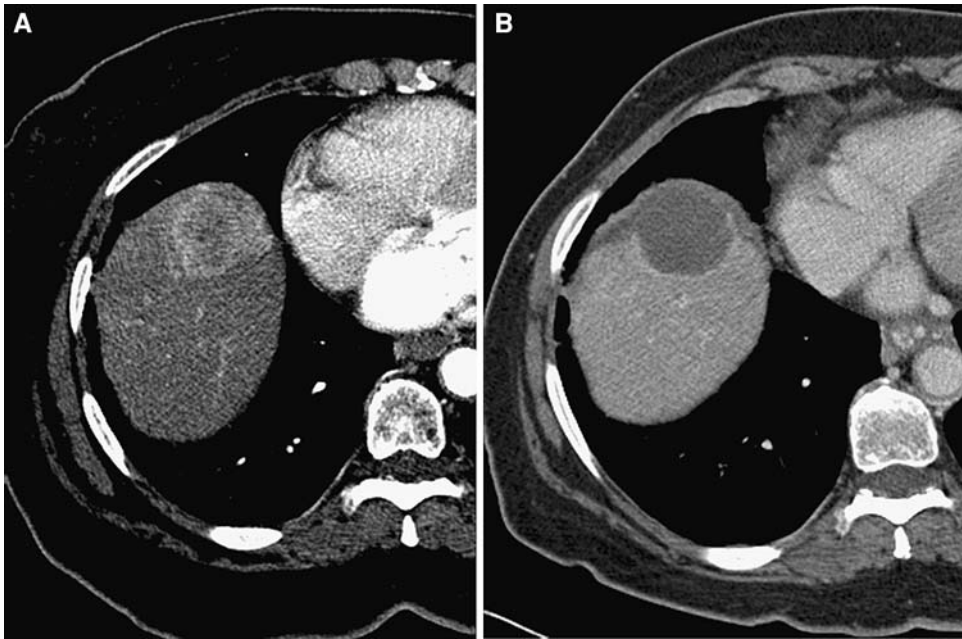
(A) Pre-treatment contrast-enhanced CT demonstrates a focal heterogeneously enhancing hepatic dome hepatoma. (B) Post-treatment contrast-enhanced CT demonstrates complete necrosis and lack of change in size of mass. Note the slight peripheral enhancement seen at the border with normal hepatic parenchyma. The peripheral enhancement is not due to tumor.
